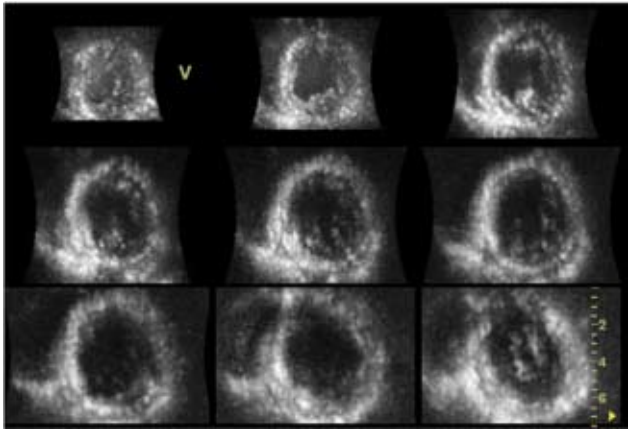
Multislice 3D echocardiography allows simultaneous visualizations of 9 short-axis images, progressing from apex (upper left) to base (lower right).
